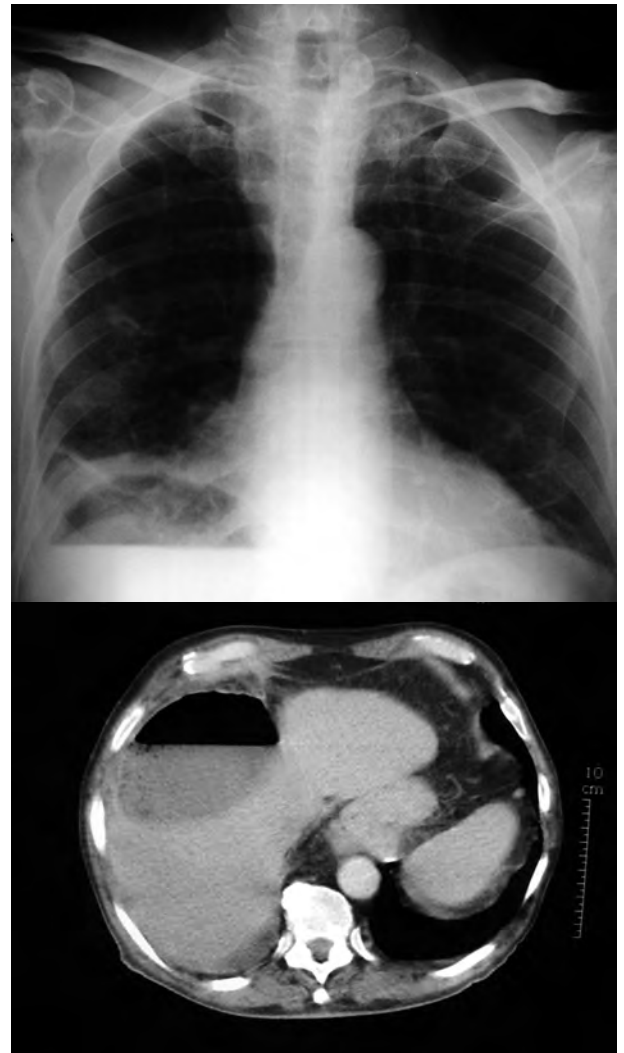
Chest X-ray (upper image) showing a hydro-aerial level in the right upper quadrant suggestive of subphrenic abscess, confirmed by CT scan (lower image).
